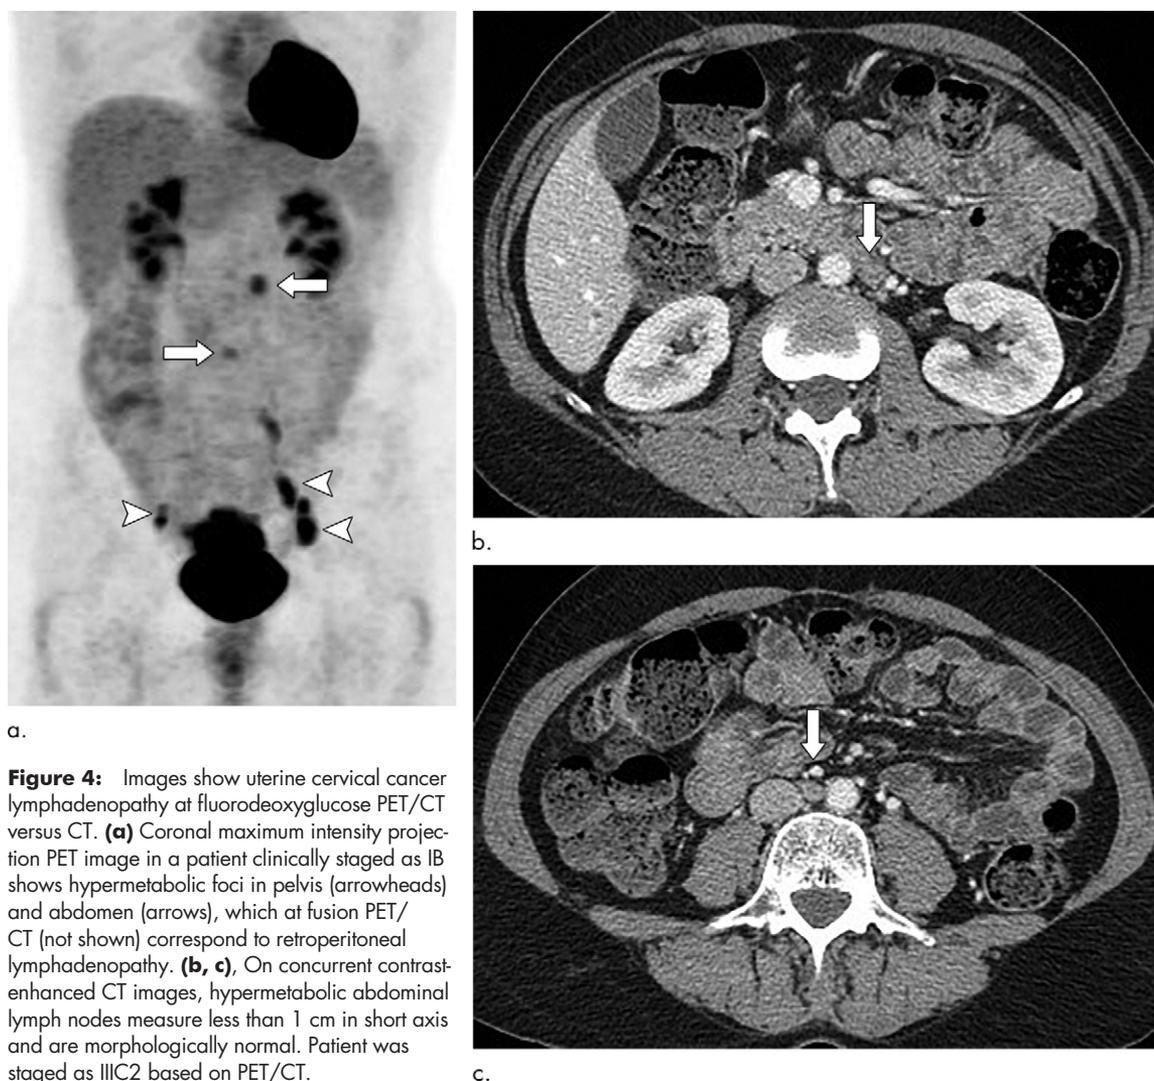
Images show uterine cervical cancer lymphadenopathy at fluorodeoxyglucose PET/CT versus CT. (a) Coronal maximum intensity projection PET image in a patient clinically staged as IB shows hypermetabolic foci in pelvis (arrowheads) and abdomen (arrows), which at fusion PET/CT (not shown) correspond to retroperitoneal lymphadenopathy. (b, c) On concurrent contrast-enhanced CT images, hypermetabolic abdominal lymph nodes measure less than 1 cm in short axis and are morphologically normal. Patient was staged as IIIC2 based on PET/CT.
